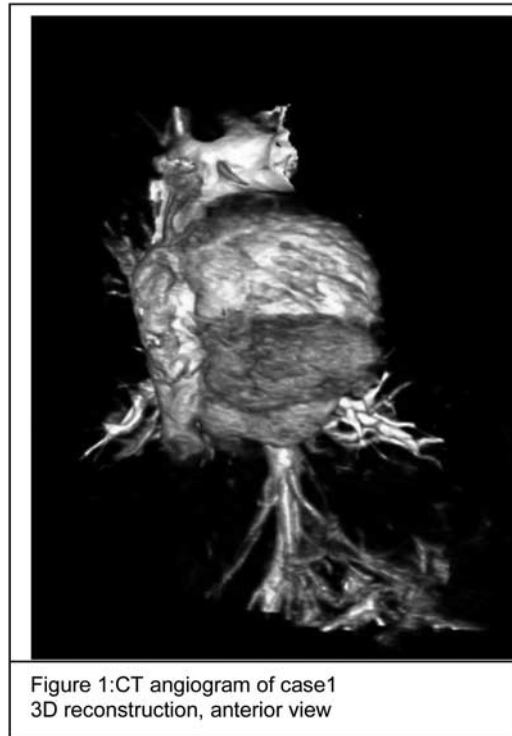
CT angiogram of case1
